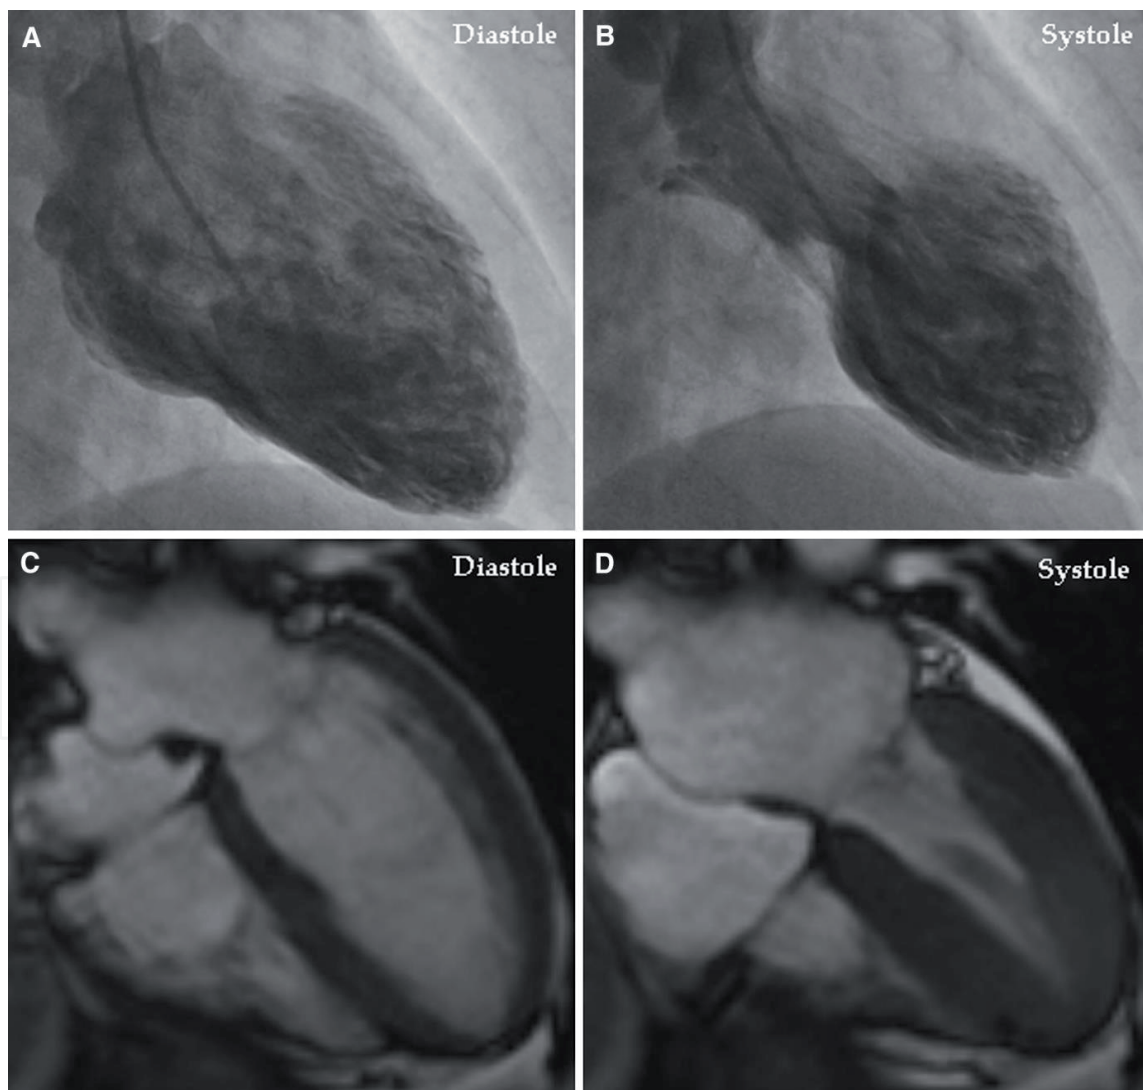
Left ventriculography during the acute stage of takotsubo syndrome shows typical midapical ballooning during systole (a) diastole, (b) systole. Cardiac magnetic resonance imaging 4 days after left ventriculography shows complete normalization of the left ventricular function (c) diastole, (d) systole. The figure is reproduced with permission from Y-Hassan et al. [3].
